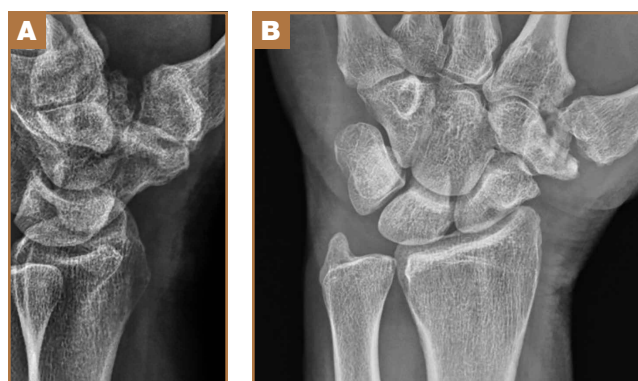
Four years after postarthroscopic partial trapeziectomy and Artelon interposition, radiographs show evidence of advancing arthritis, central trapezoidal destruction, and rim osteophyte formation. (A) Betz view; (B) anteroposterior view.
